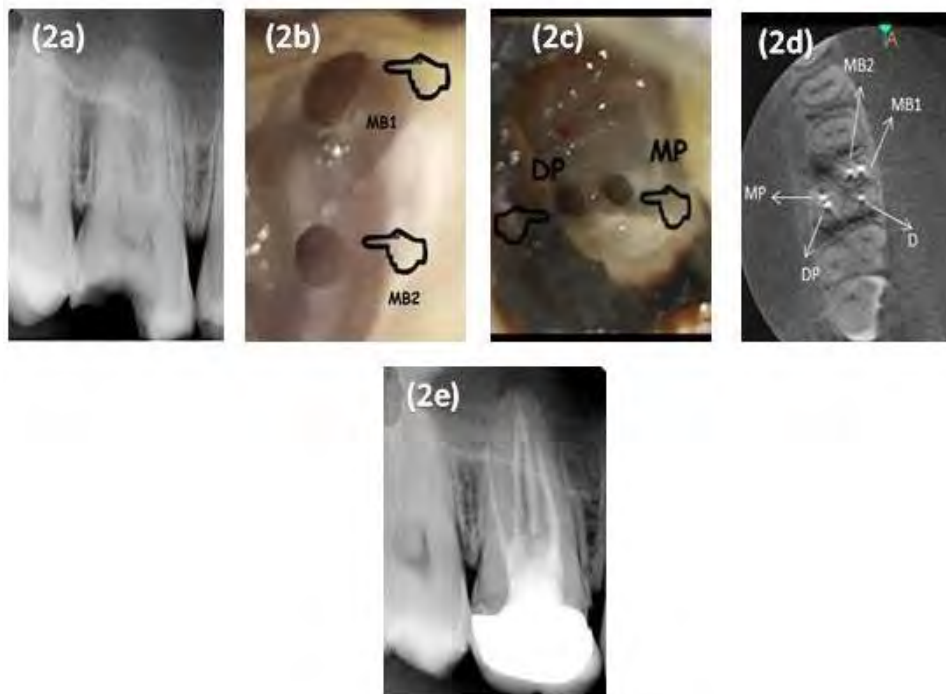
Tooth #16. (2a) Pre-operative IOPAR, (2b, 2c) MB1, MB2 and MP, DP canal orifices, (2d) Post-operative CBCT axial view, (2e) Post-operative IOPAR with crown
